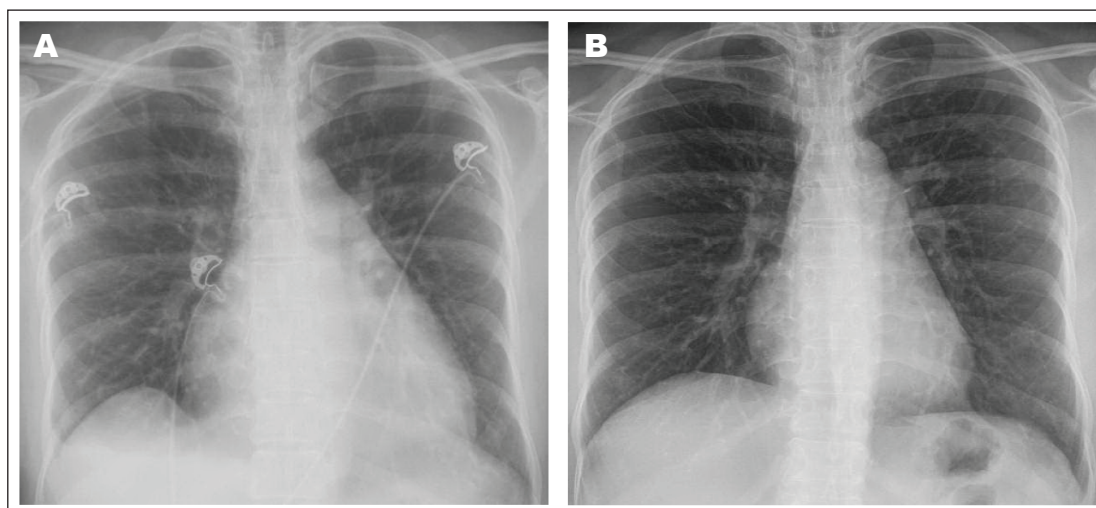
Posterior-anterior view of chest X-rays at (A) initial presentation and (B) 18 months later.
